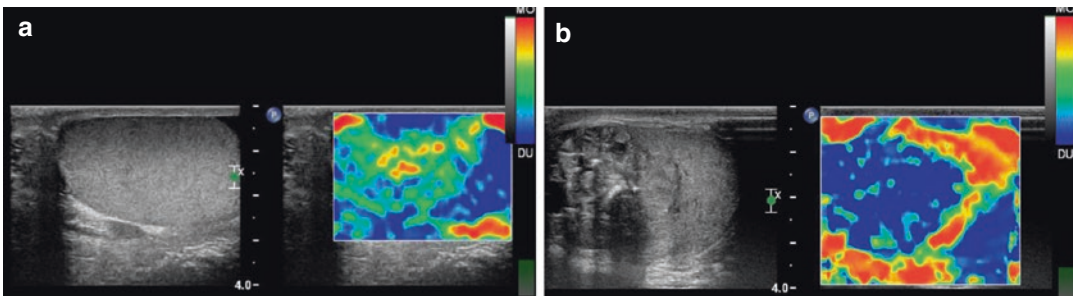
Elastasonography. (a) A normal testicle has a medium level of elasticity (displayed in *green*), while malignant lesions (or epidermoid cysts as in b) appear as
